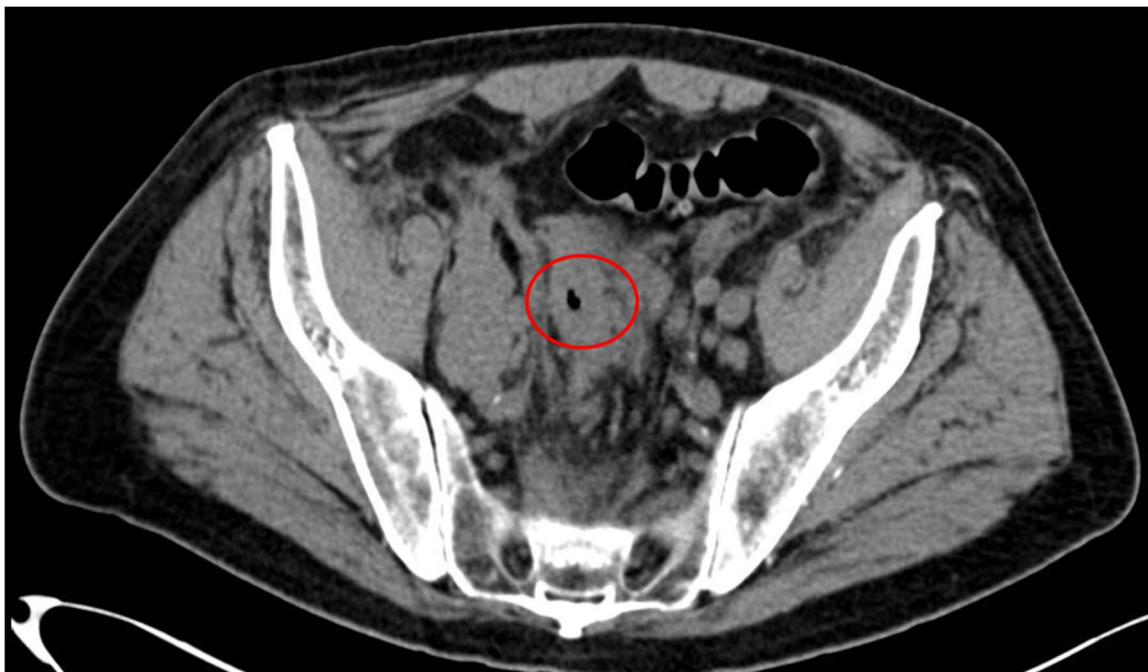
Abdominal CT scan. Circumferential thickening of the colonic wall located at the recto-sigmoid level
